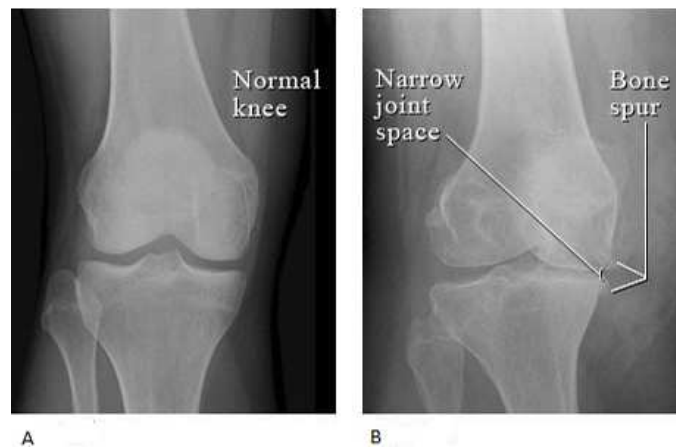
X-ray of a normal knee with space between the bone of the upper and lower leg (A). (B) shows bone spurs and a narrowed joint space caused by osteoarthritis [4]
